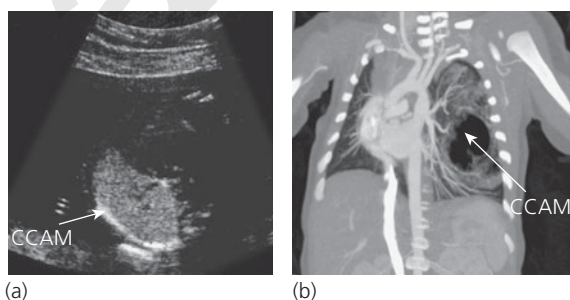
Prenatal diagnosis of congenital cystic adenomatoid malformation (CCAM) and reconstruction computed tomography scan of a large CCAM of the left upper lobe.
